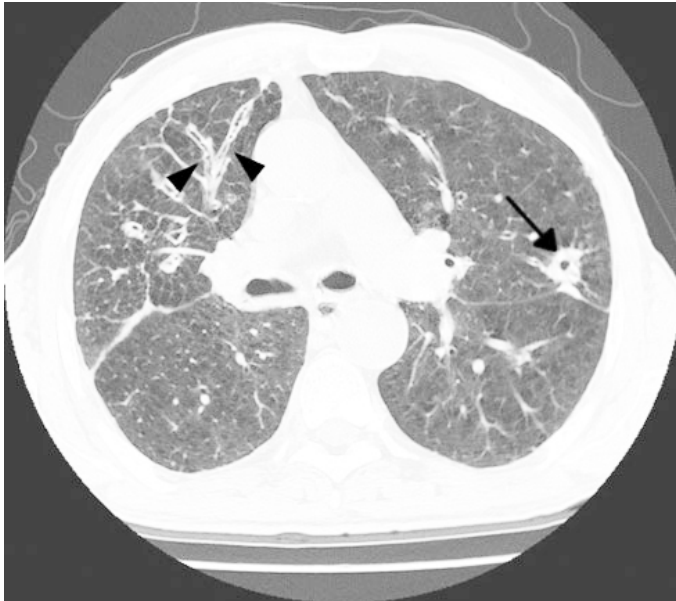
Wegener's granulomatosis. Thin section CT scan at carina shows cavitating nodule in the lingular division of the left upper lobe (arrow). Bronchial wall thickening is evident in the right middle lobe (head arrows).
